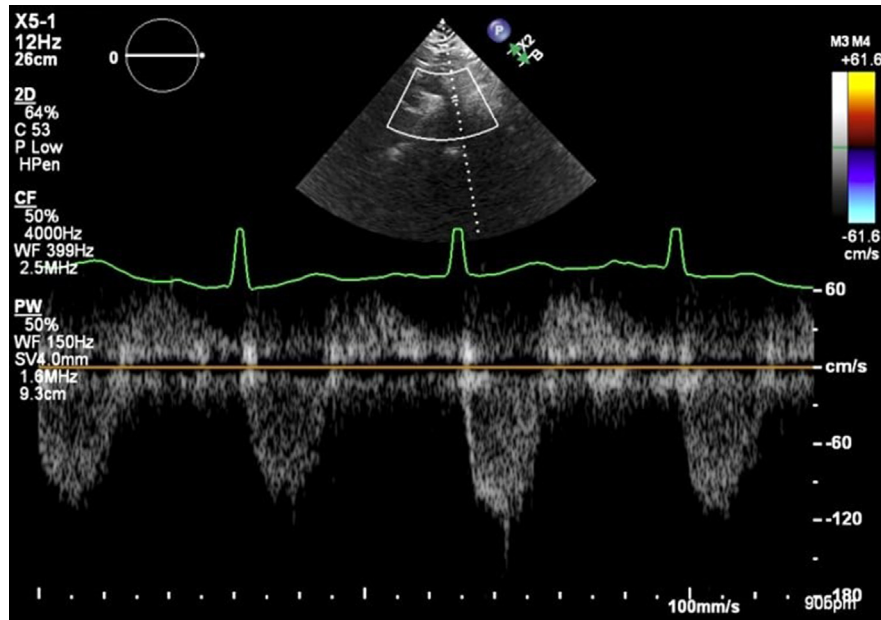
Two-dimensional TTE, suprasternal notch view, pulsed-wave Doppler through the descending thoracic aorta, demonstrates significant holodiastolic flow reversal indicative of severe AR.
